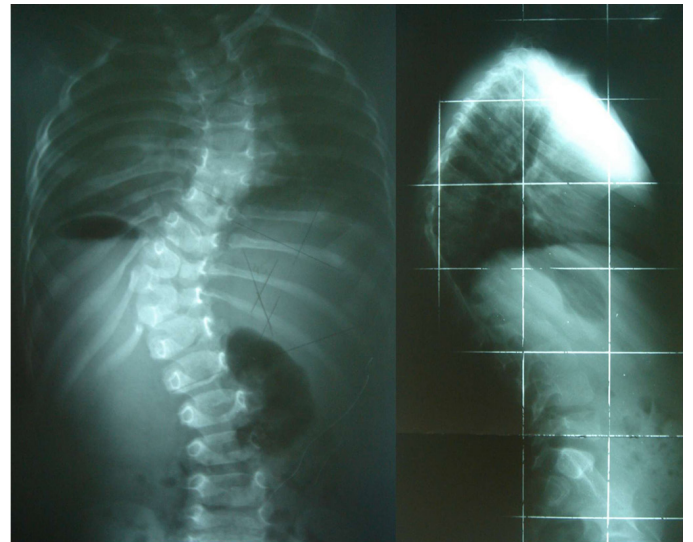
Case 2 - AP and lateral X-Ray views of the spine at two years of age – hemivertebrae, butterfly vertebrae and rib fusion and a main Cobb angle of 45°.
